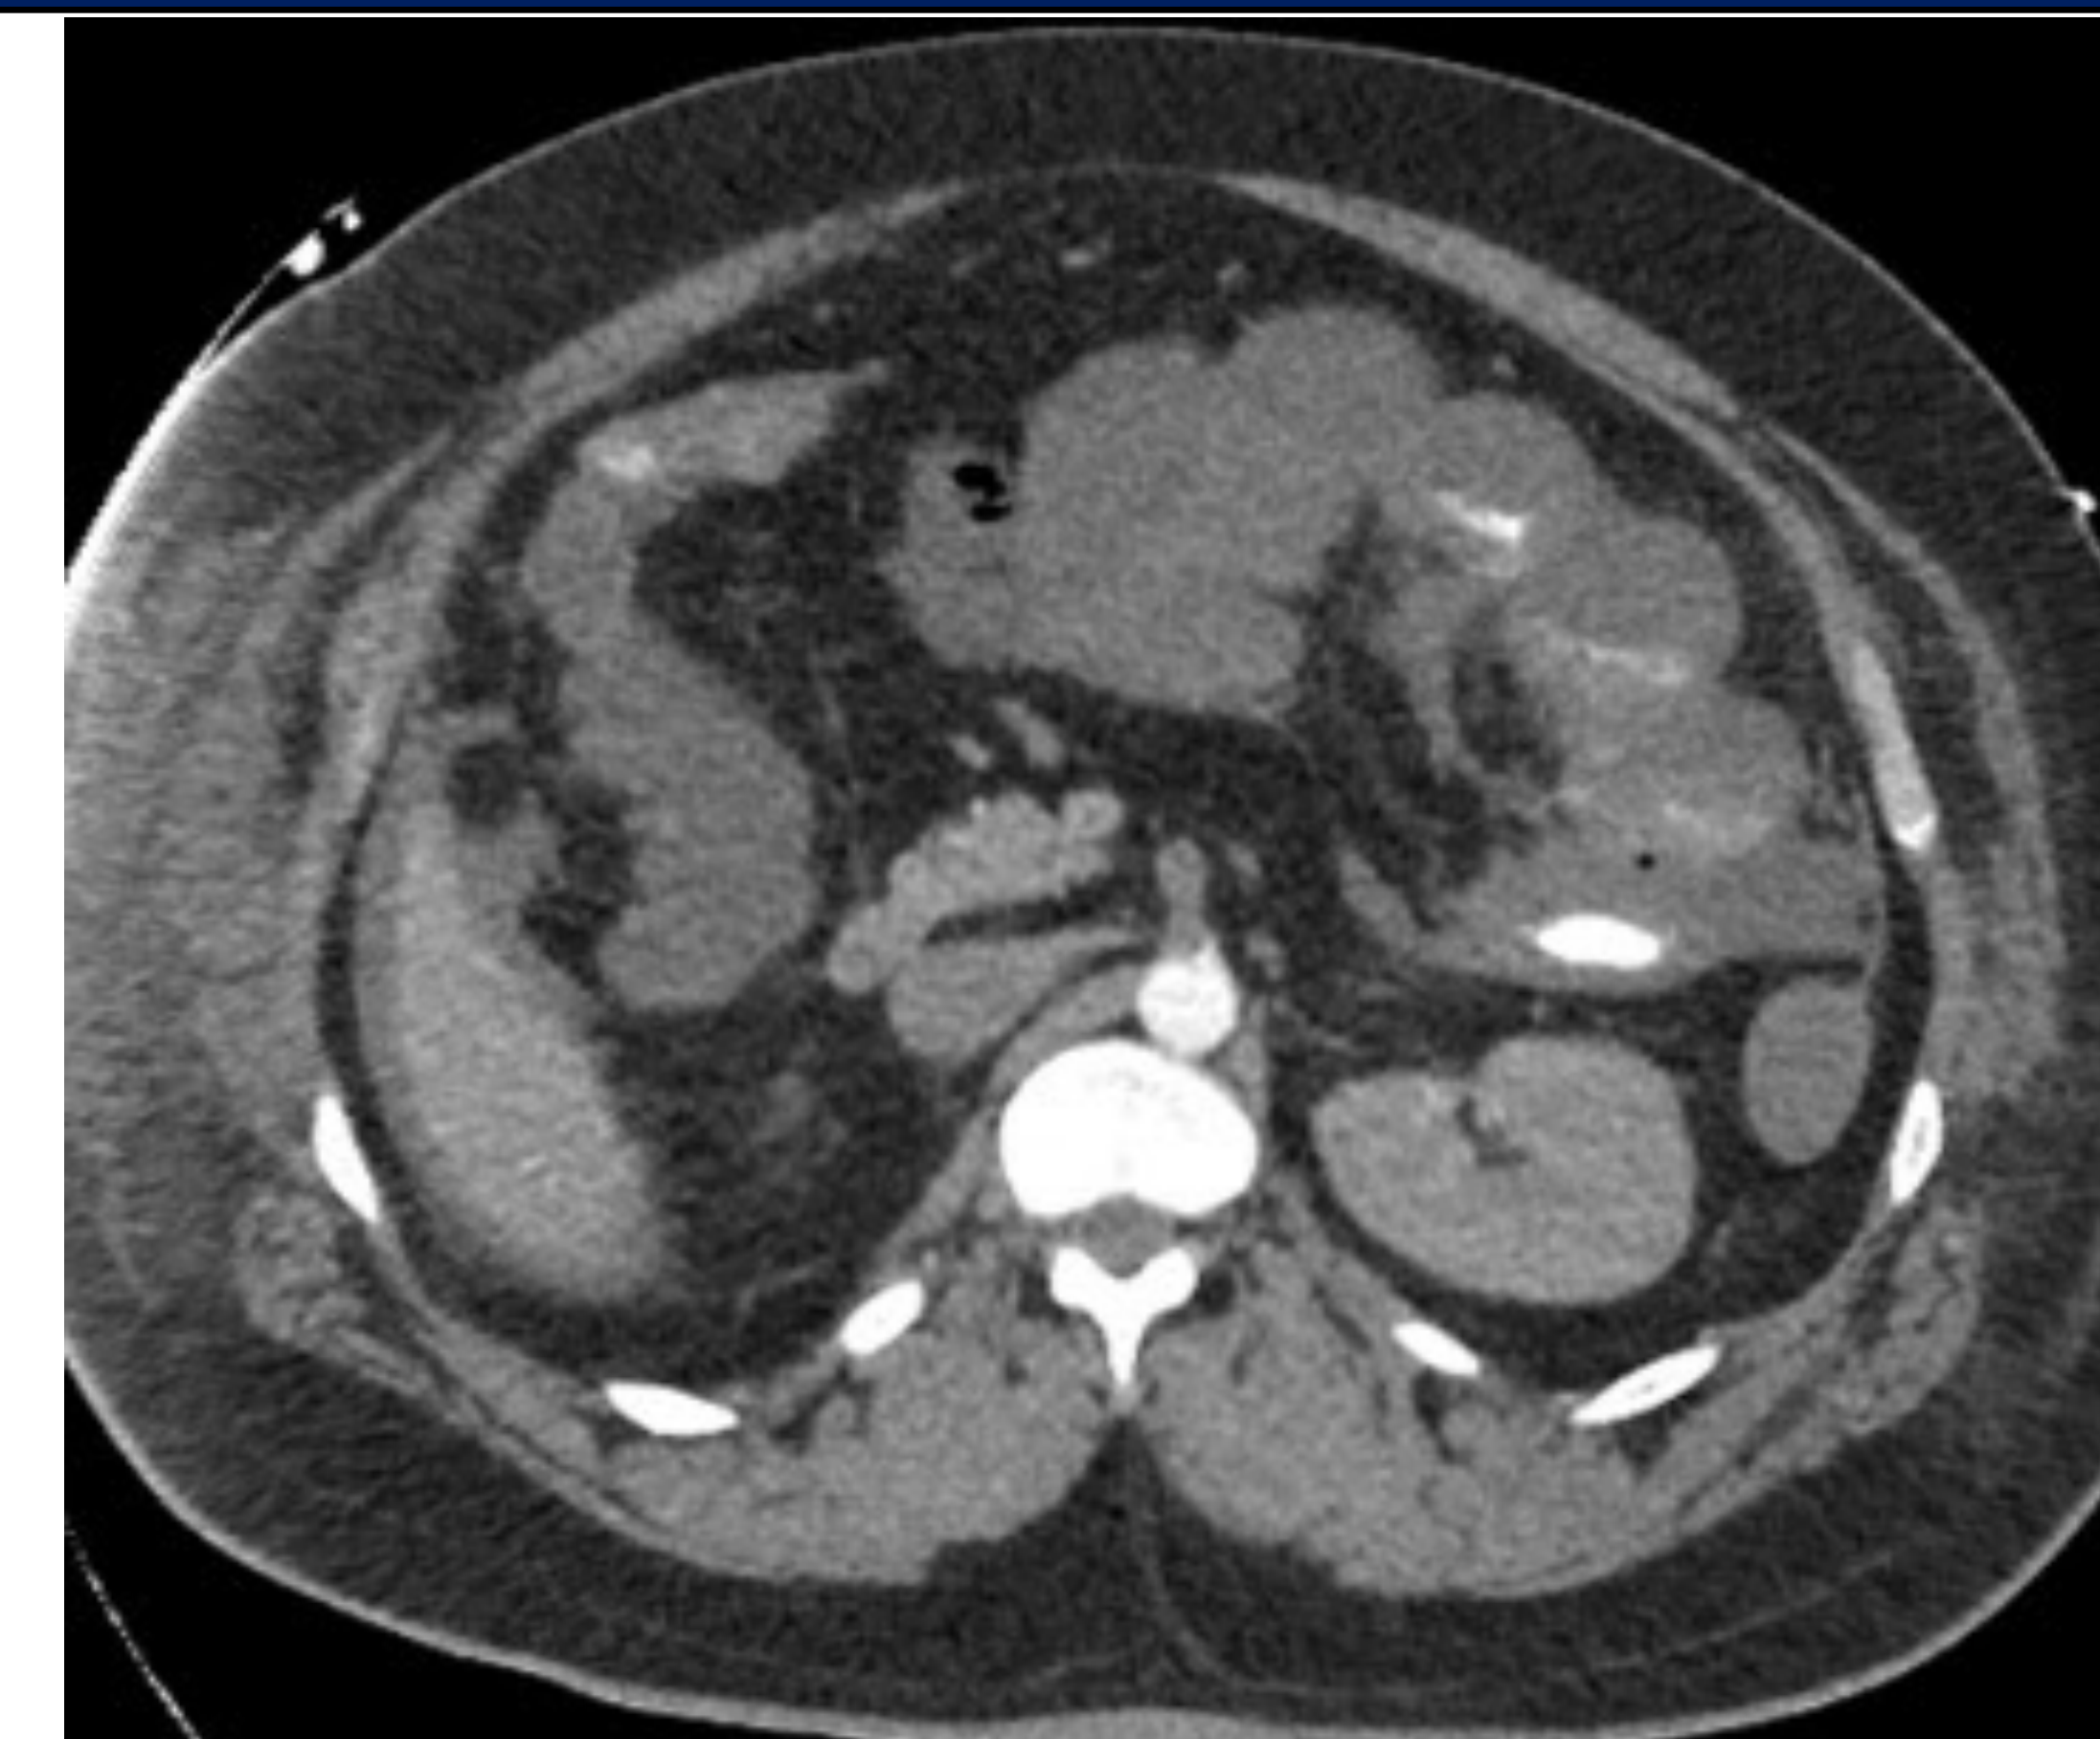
CTA of abdomen: thrombus with complete occlusion of superior mesenteric artery at its origin.
